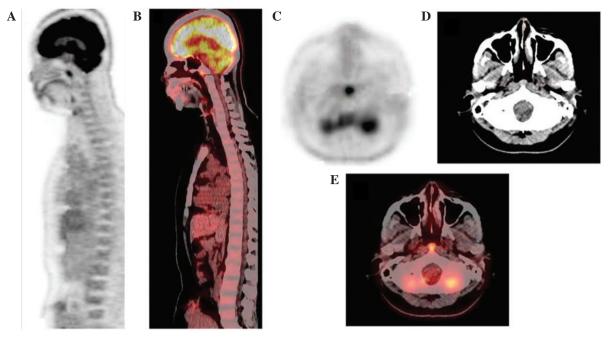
Coronal (A) PET and (B) fused PET/CT scans, as well as axial (C) PET, (D) CT and (E) fused PET/CT scans revealing a focal hot lesion (maximum standard uptake value, 6.2) located at the roof of the nasopharynx and measuring ~1 cm in size. PET, positron emission tomography; CT, computed tomography.
